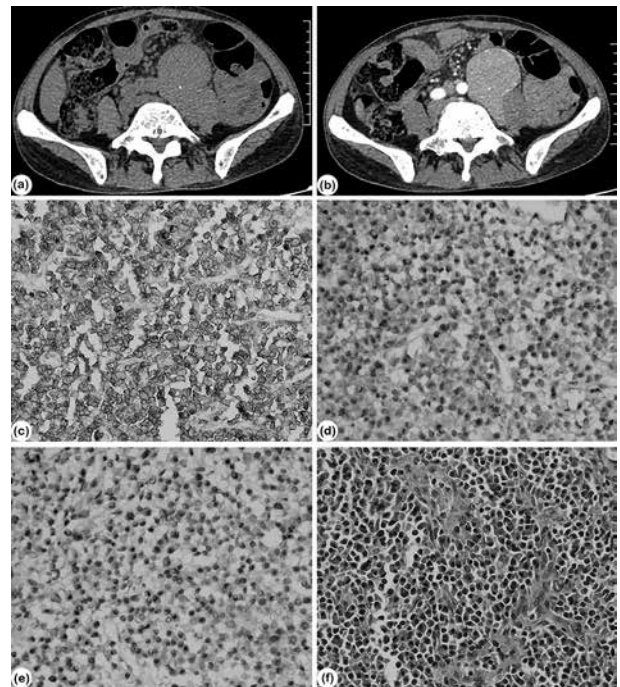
(a) Punctate calcification in the lymph nodes. (b) Blood vessels in the rim of the lesion and the computed tomography value increased. (c) Infiltration of CD38(+) plasma cells. (d-e) IgG4+/IgG+ plasma cells $>40\%$. (f) Tubular thickened vascular walls (H-E $\times 10\times 40$). IgG: Immunoglobulin G.
